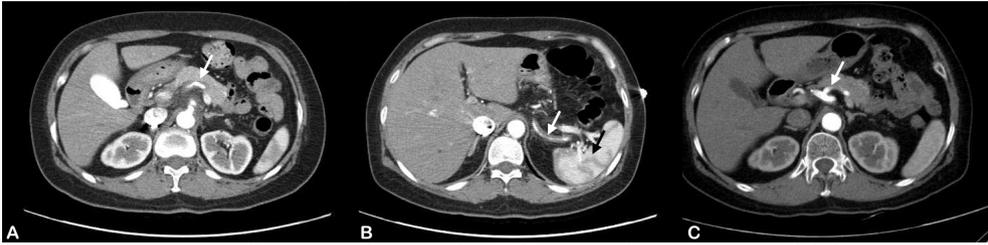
Immediate endovascular intervention. A) Initial computed tomography (CT) scans showing celiac artery dissection extending to the splenic artery (arrow). B) Long dissection covering most of the splenic artery (arrow) with spleen hypoperfusion. C) CT scan 36 months after stent insertion showing near complete regression of the intimal flap.
